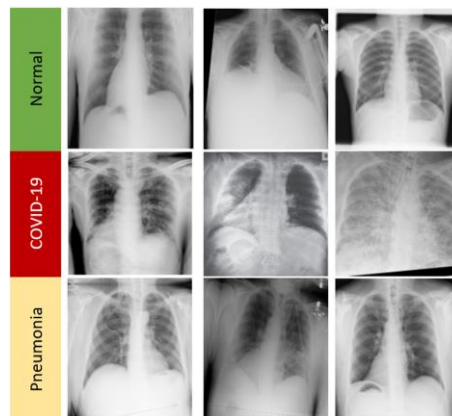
Chest X-ray images samples from the prepared dataset
